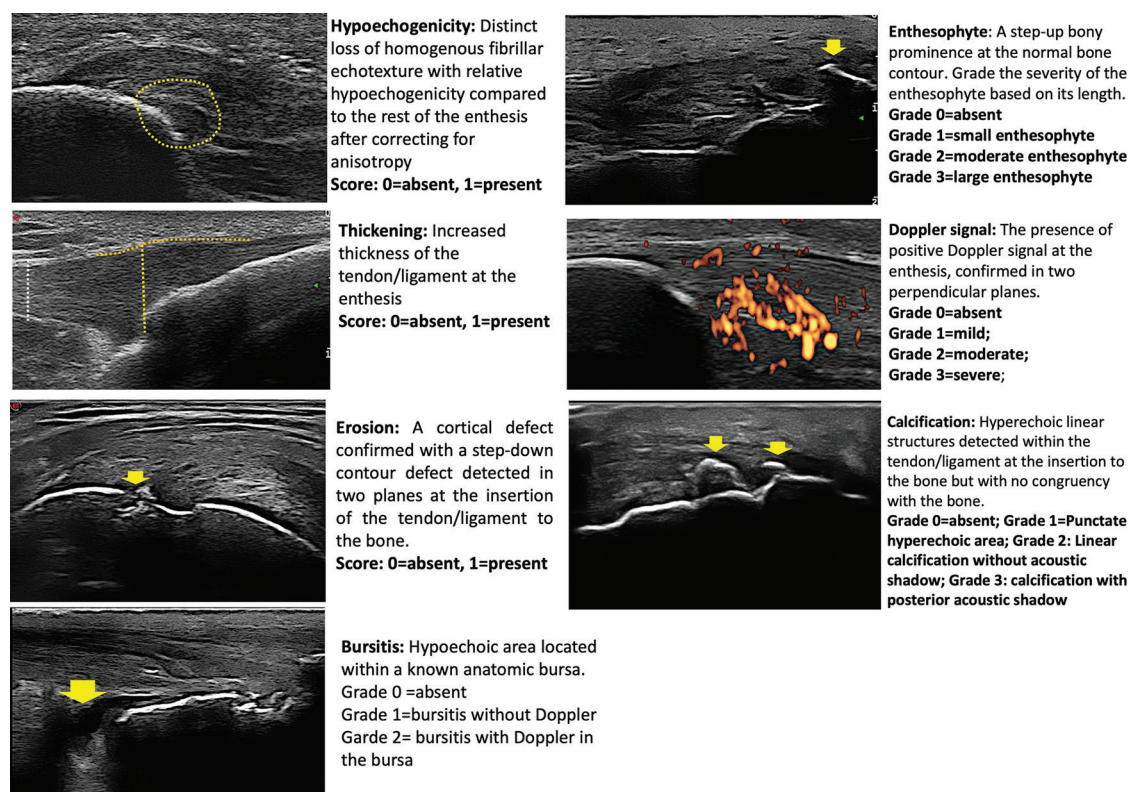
Scoring of sonographic elementary lesions in the DUET study.¹¹
